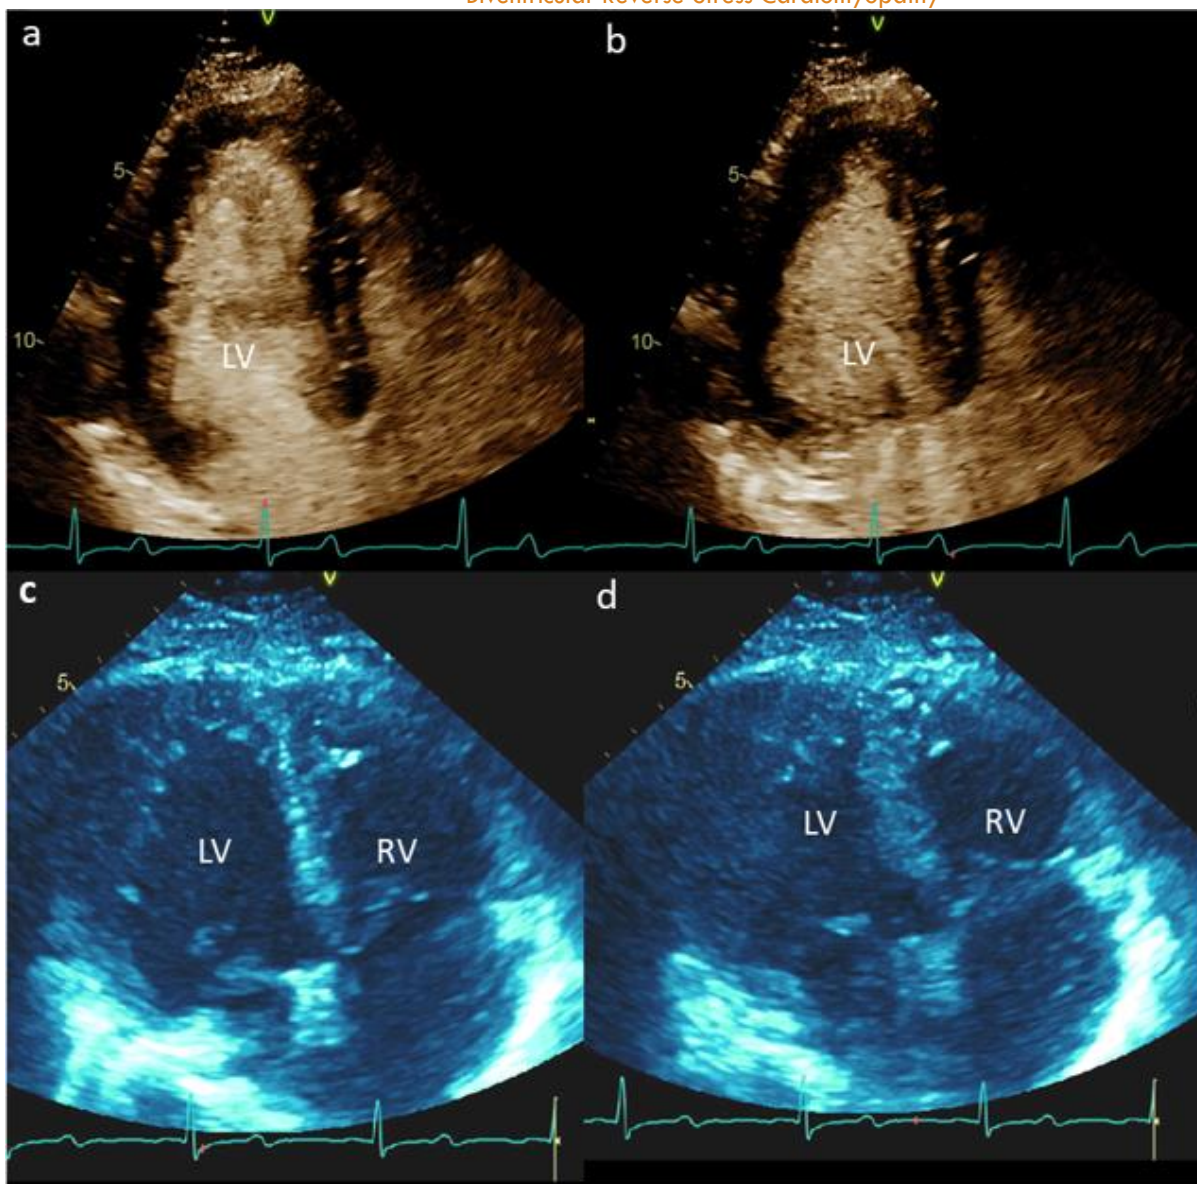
Apical four-chamber view in end-diastole (a) and end-systole (b) demonstrating reduced basal and mid left ventricular function and relatively preserved apical function (arrows), ejection fraction 25%. Right ventricular focused views in end-diastole (c) and end-systole (d) demonstrating right ventricular enlargement and reduced systolic function.
